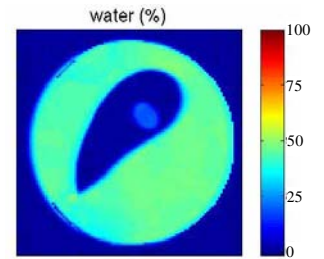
Water concentration map obtained by 3PD MRI.
